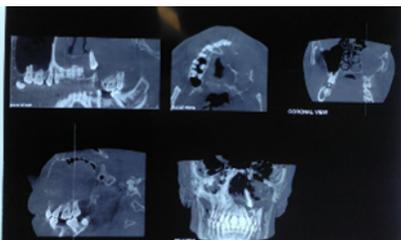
Pre operative CBCT Showing the extent of the lesion
